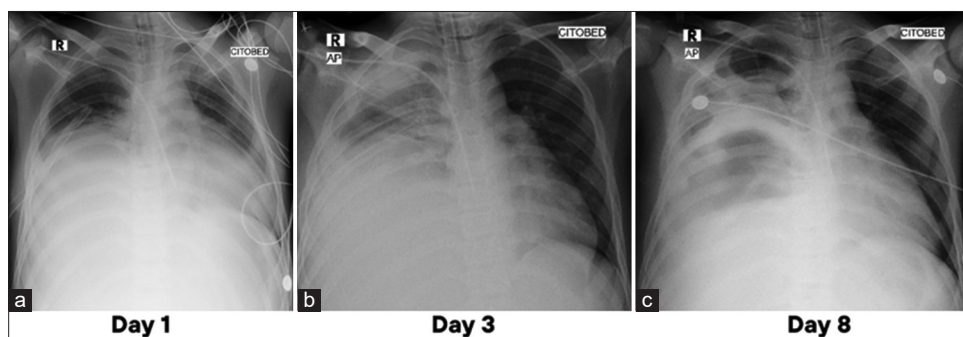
Evaluation of pulmonary infection progression through chest X-ray imaging. (a) Infiltrates observed in the right and left perihilar regions (pneumonia) with bilateral pleural effusion; (b) Postoperative chest X-ray after the first surgery showing right hemithorax infiltrates and organized right pleural effusion; (c) Follow-up chest X-ray after the second surgery revealing persistent organized right pleural effusion
